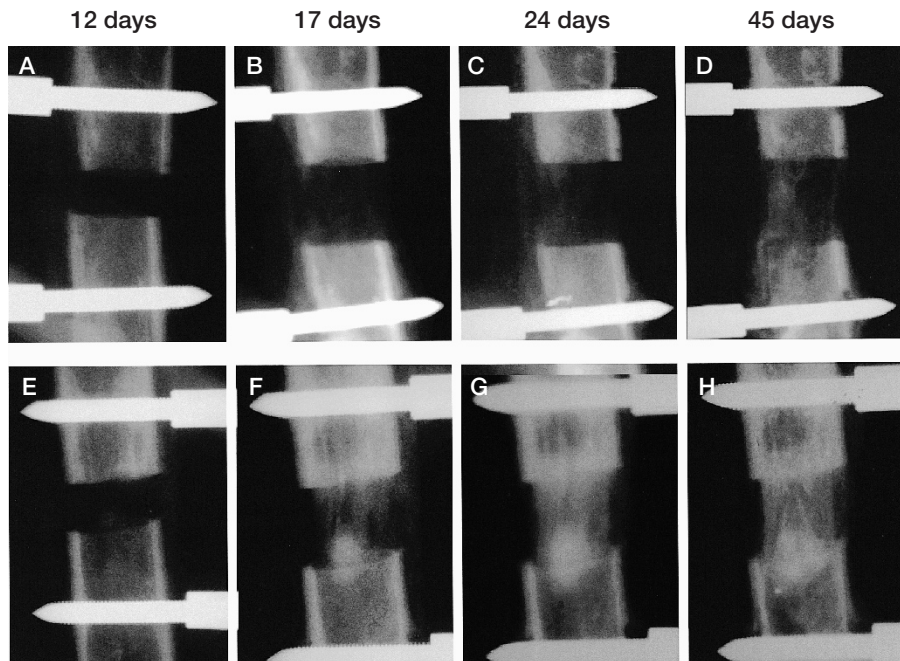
Typical radiographs of the lengthened tibia on the 2-step side (A to D) and on the 120-step side (E to H).
